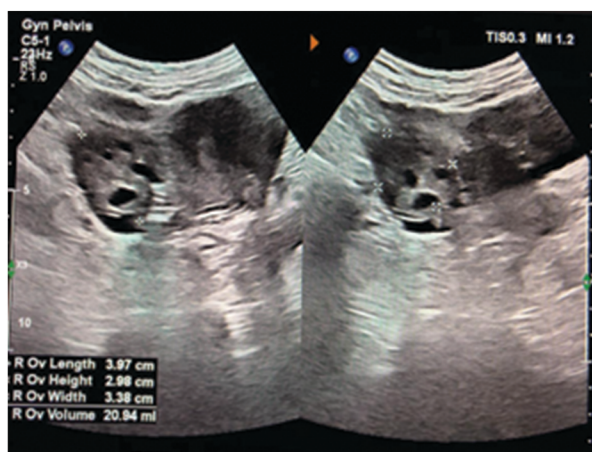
Repeat sonogram showing multi cystic ovary with improved ovarian size compared to pre-treatment scan
